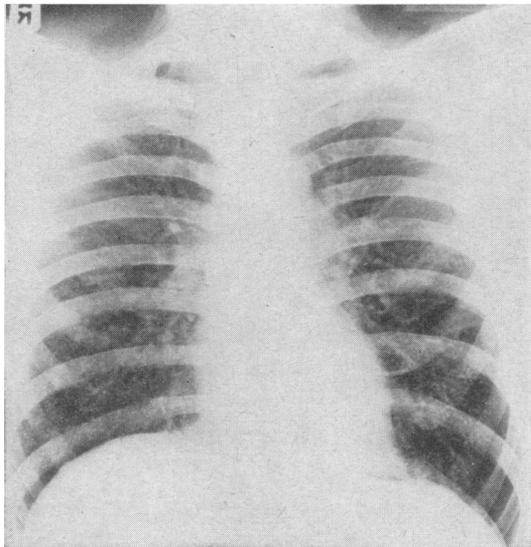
Case 2. Chest radiograph showing generalized mottling in both lungs.
